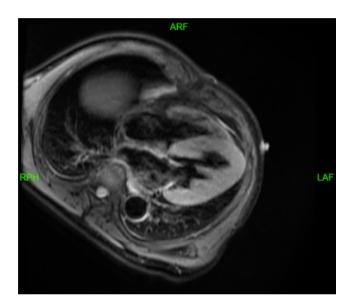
Cardiac MRI (four chamber, T2WI + Black Blood).
